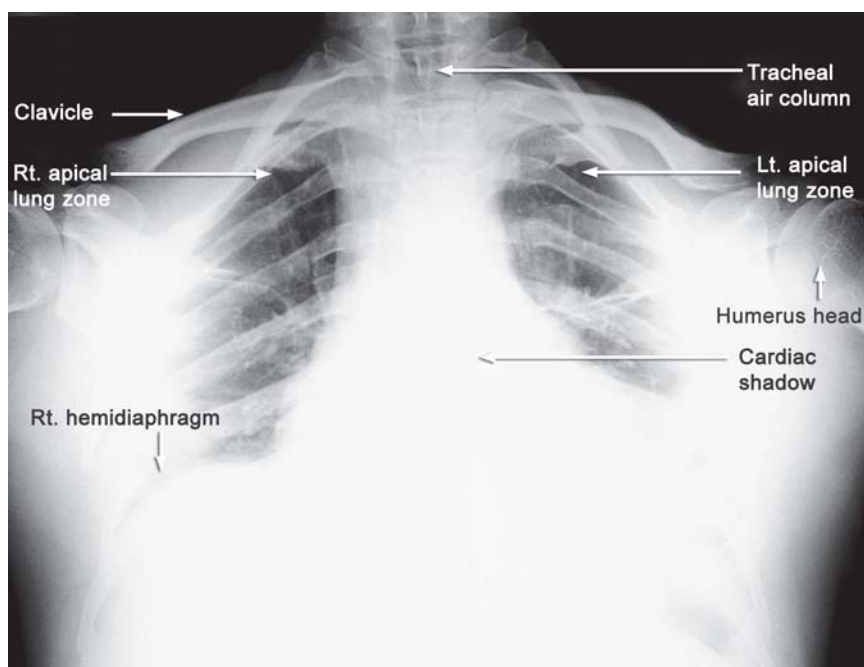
X-ray chest – apicogram
